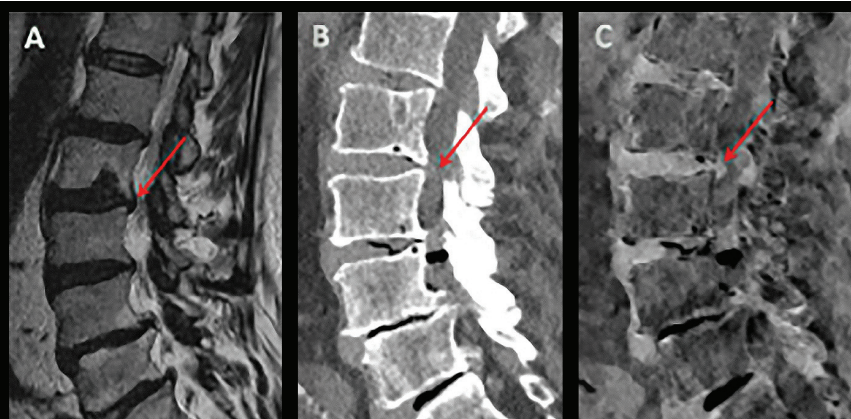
Figure A Sagittal (T2) MRI image shows L2-L3 disc herniation (arrow).
